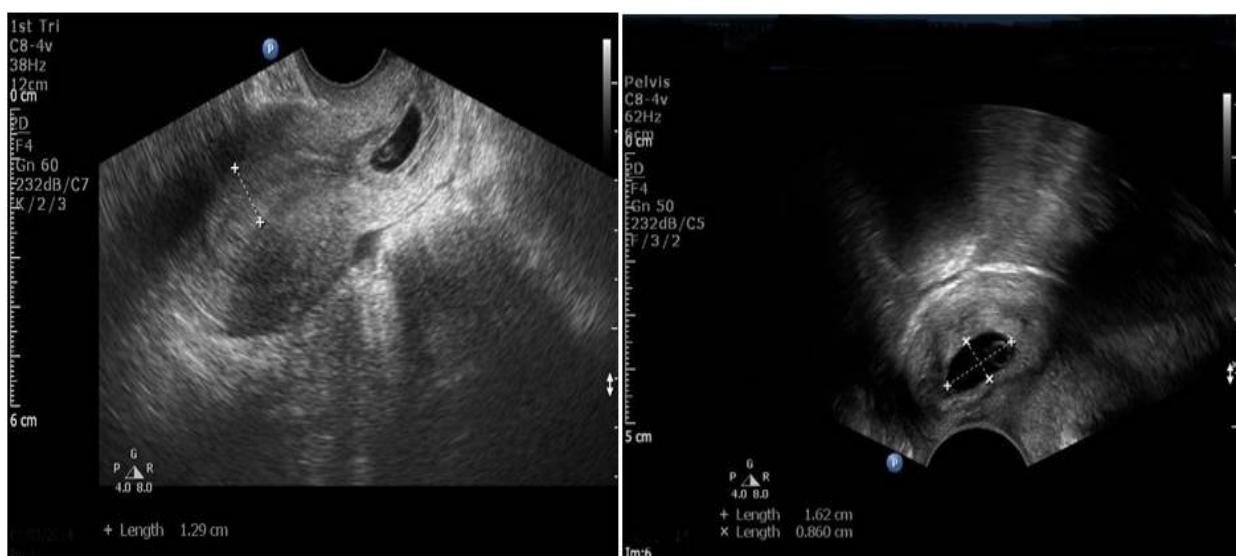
The trans-vaginal ultrasound scan picture on day 3 of treatment showing a regular sac in the cervix. Heart pulsations were absent.
